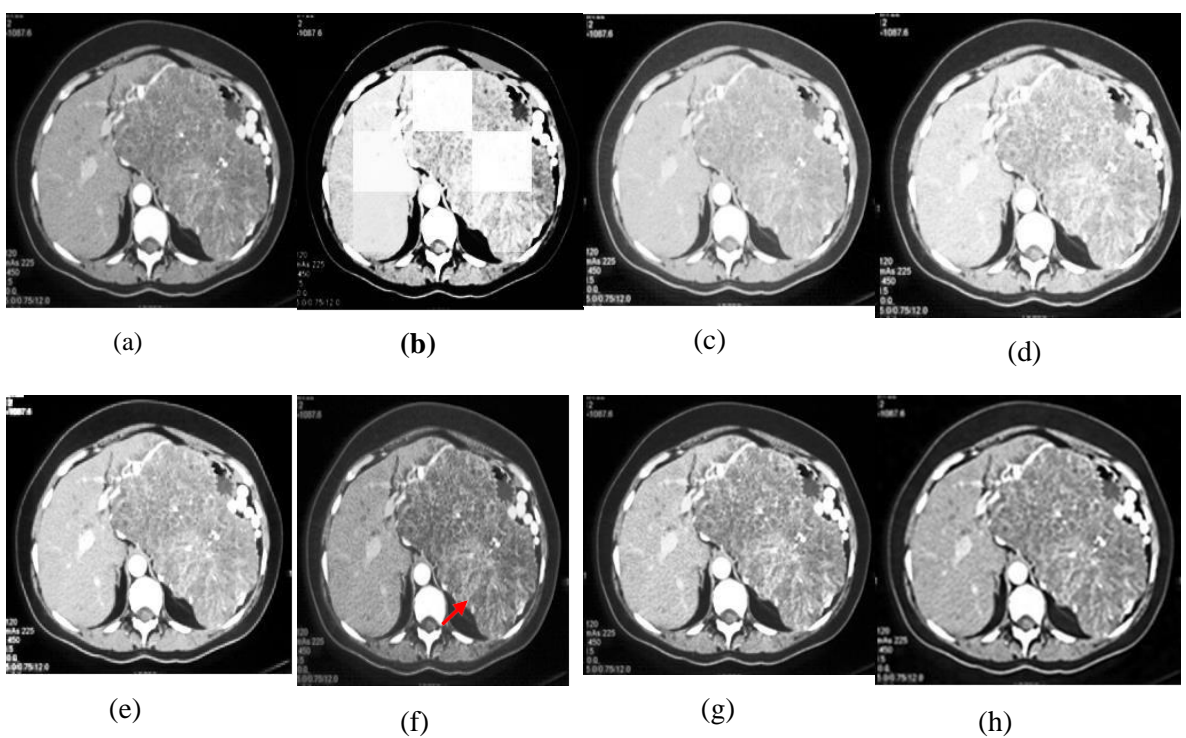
Experiment outcomes of the ‘CT-6’ Image (a) Original image, (b) S-curve, (c) AGC-DWT, (d) AGC-WHD, (e) GAGC-DWT, (f) EBCHE, (g) TCHE-DWT, (h) Proposed scheme
